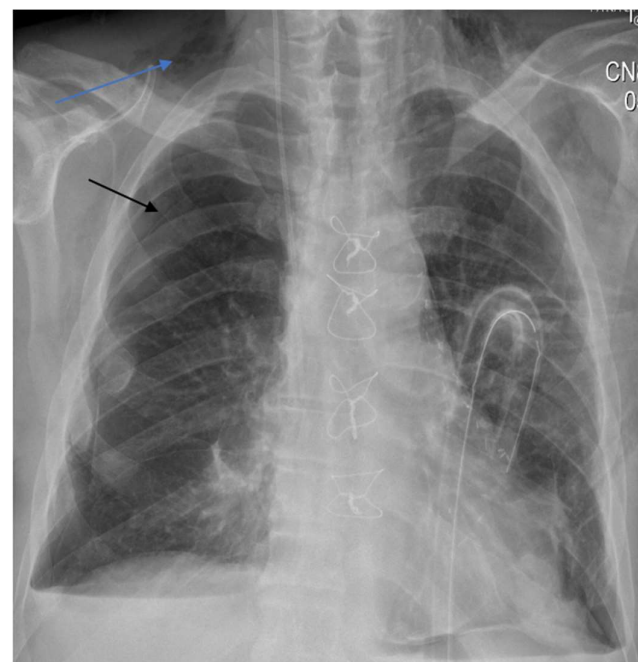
The X-ray of the right-sided pneumothorax as the complication of insertion of CVC. (black arrow); Right-sided subcutaneous emphysema (blue arrow) as another complication of insertion of CVC.
